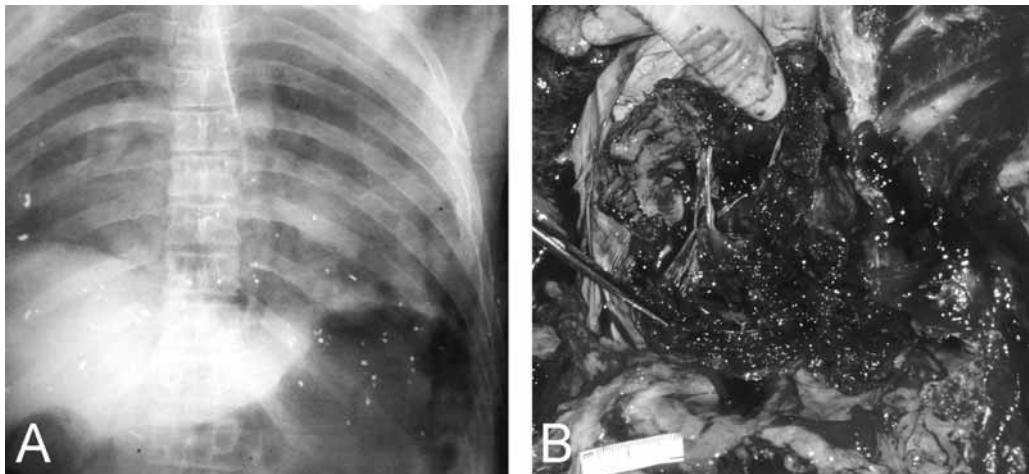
High velocity hunting rifle used to commit a homicide. (A) Radiograph: “snow-storm” pattern owing to fragmentation of the bullet. (B) Considerable destruction of heart in wound path, a reflection of the large temporary cavity created during passage of the projectile. (Courtesy of the office of the Chief Medical Examiner, Chapel Hill, NC.)
